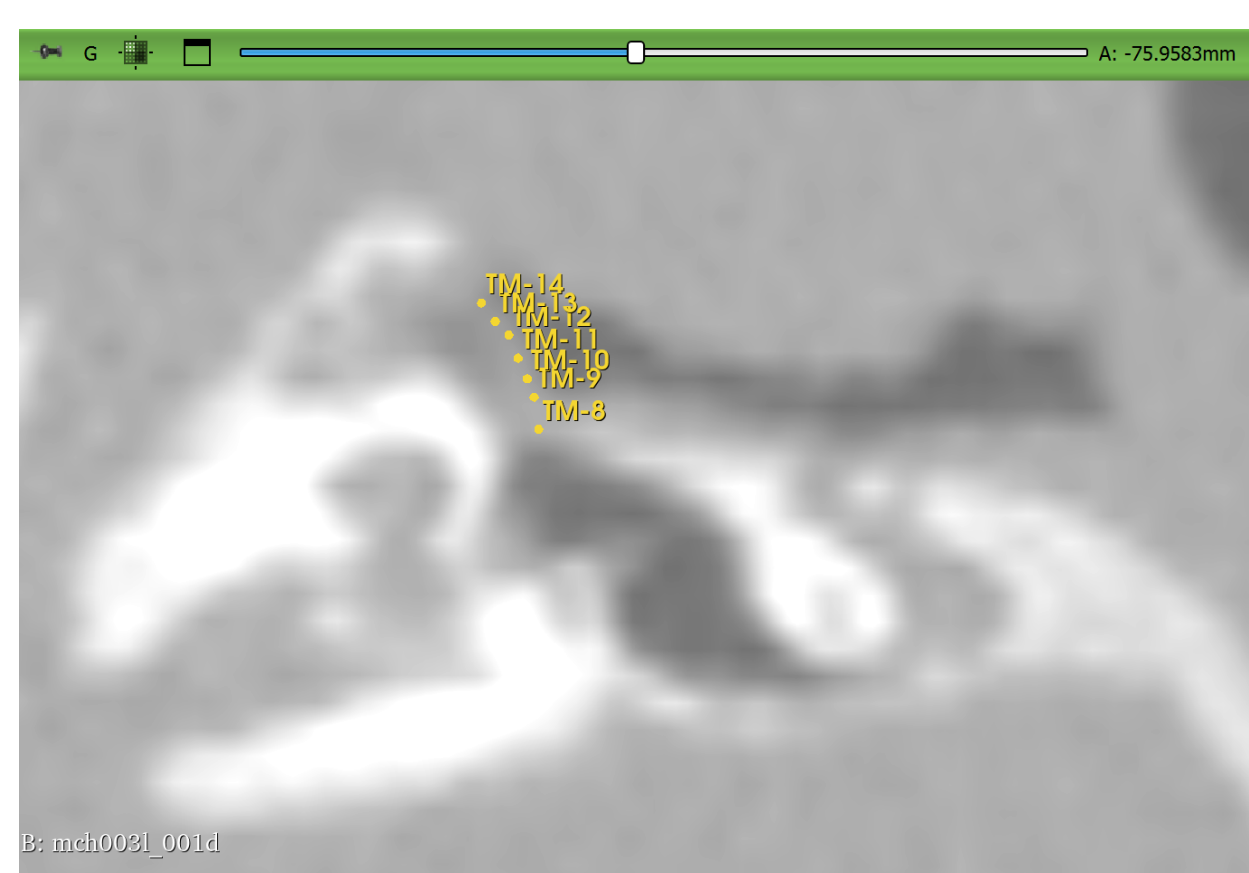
Screenshot from Slicer after CT volume has been rotated to clearly show the manubrium
